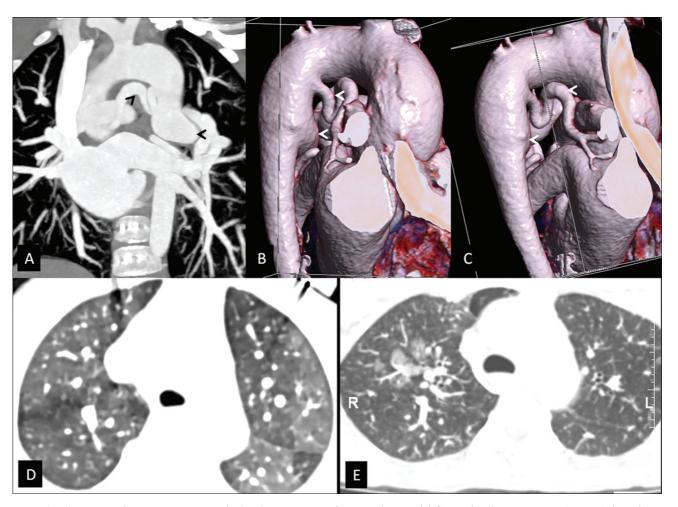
(A–C). Computed tomogram angiography (CTA) in a patient with ventricular septal defect with pulmonary atresia (VSD-PA) shows large aortopulmonary collateral arteries (arrowheads) arising from descending thoracic aorta. (D) CT image in lung window showing differential lung attenuation in the same patient. (E) CT image (lung window) from a different patient with VSD-PA and hemoptysis showing ground glass attenuation in right upper lobe.
